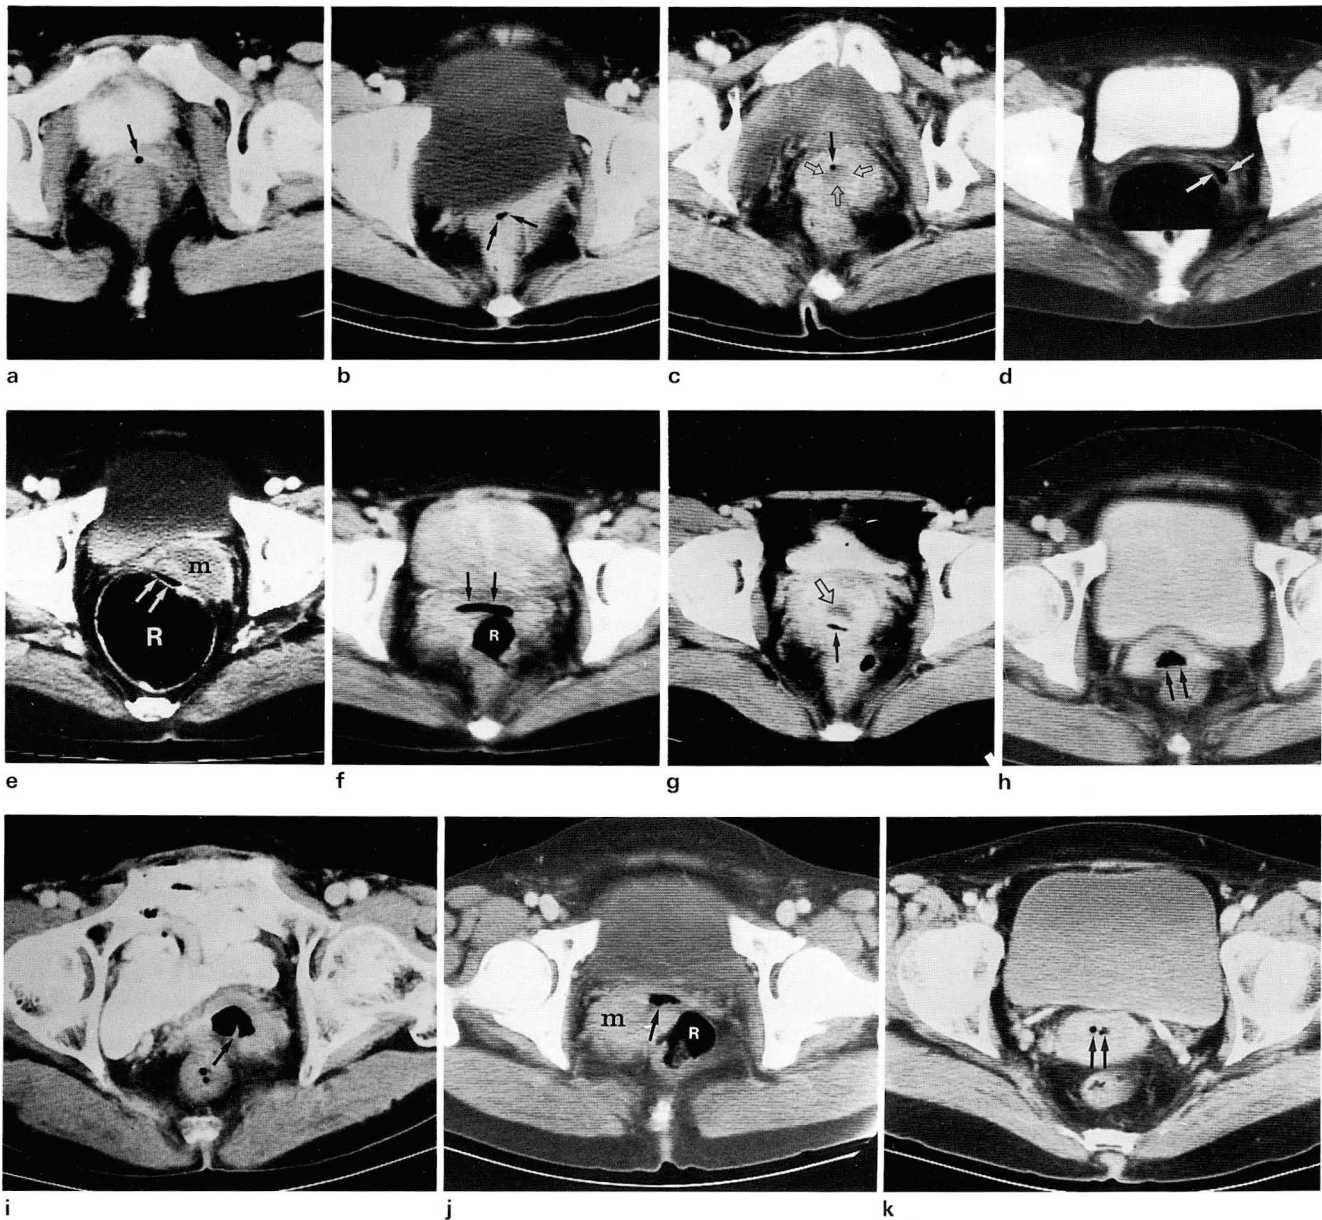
Types of vaginal air seen on CT scans of pelvis in patients with uterine cervical carcinoma.
